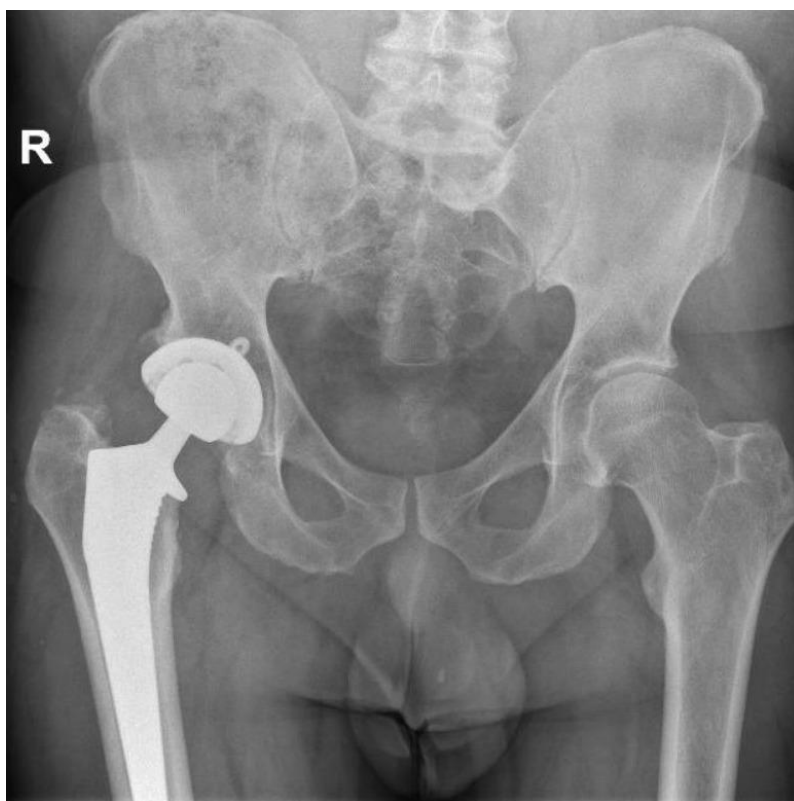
Post-operative X-ray showing good position of the revised THR.
